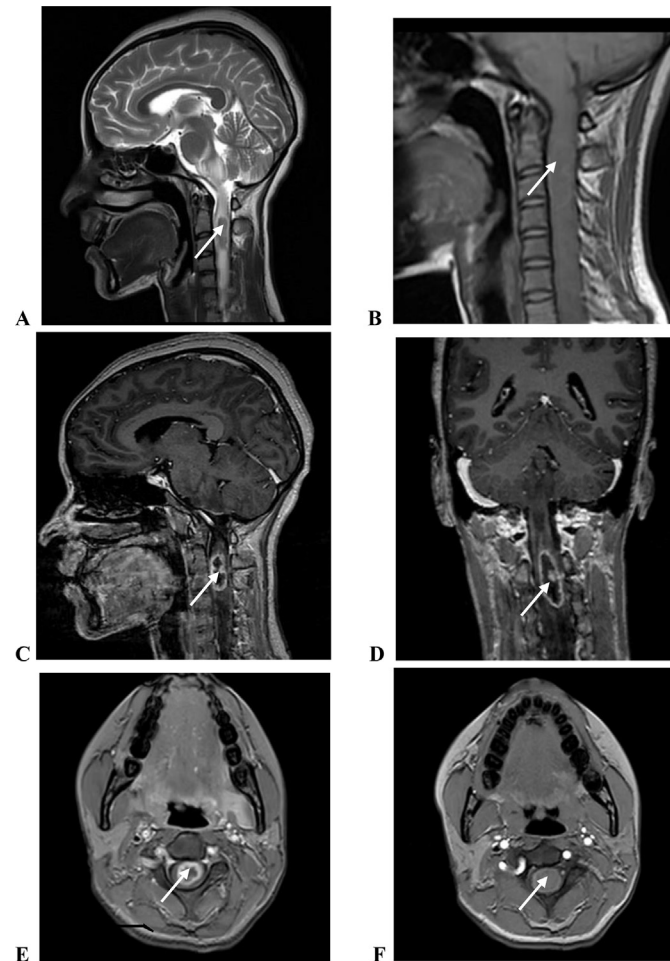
Twenty-year-old female with caseous stage spinal TB. MRI findings of the brain and cervical spine reveal an intramedullary well defined mass lesion measuring 27 × 12 mm in the cervical cord between C2 and C4 vertebral levels. On the sagittal T1 images, the region appears iso-intense (arrows, A, F), while it is hypointense on T2 images (arrow, B). Postcontrast images show peripheral ring-like enhancement, indicated by the arrow (C, D, E). Additionally, the T2 images display marked adjacent hyperintensity extending up to the level of the medulla, along with adjacent edema.
